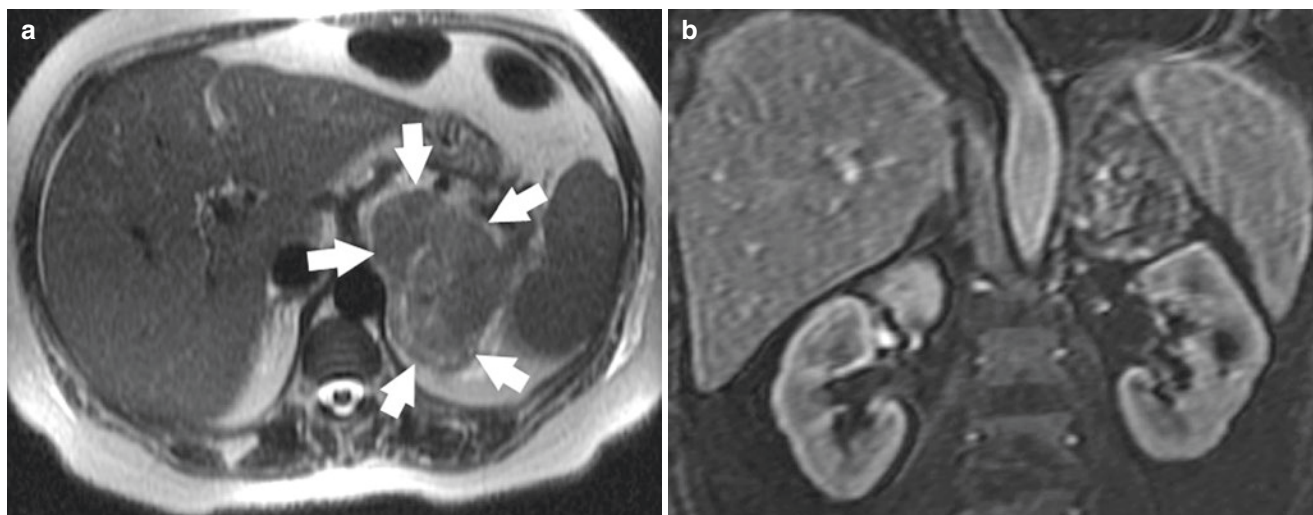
Selected images from the MRI of the patient discussed in the initial case report: (a) axial image; (b) coronal image of the 7 cm left adrenal pheochromocytoma (borders of which are denoted by arrows), which caused a hypertensive crisis
